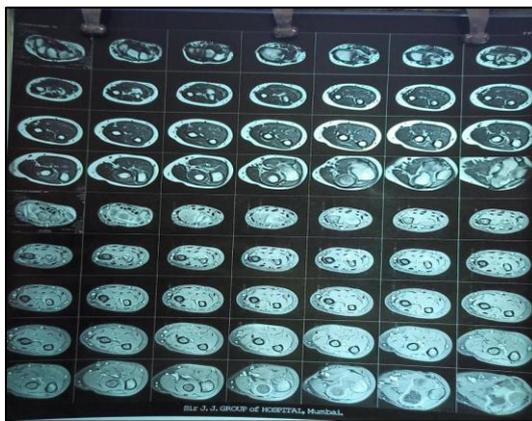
Distal ulna osteomyelitis MRI radiograph axial view.
